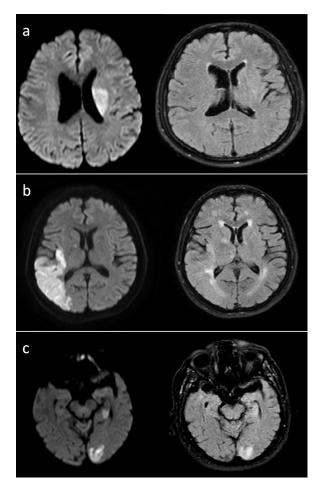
Examples of ischemic lesions; Diffusion-weighted imaging (DWI) images show acute ischemic lesions (left column). Corresponding intensity patterns appear in the Fluid-attenuated inversion recovery images (FLAIR) images (right column); no hyperintensity (a), slight hyperintensity (b), bright hyperintensity (c).
